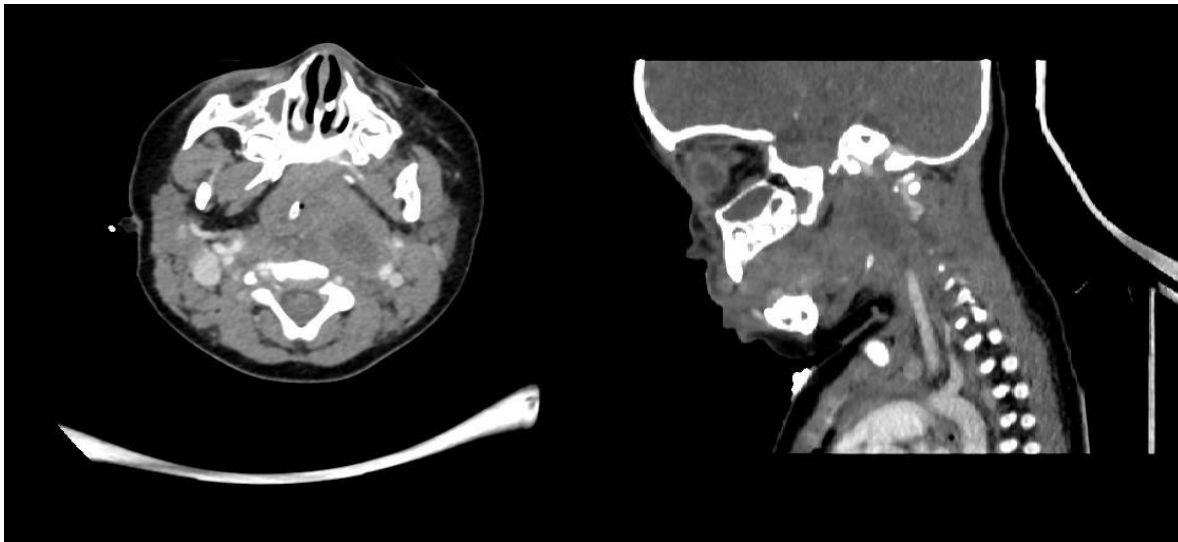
Magnetic resonance images of the retropharyngeal abscess.
